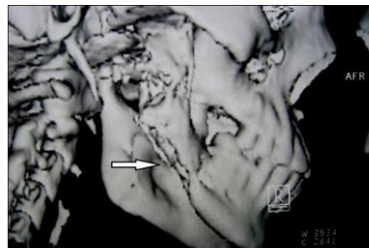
reconstruction of CT scan .
